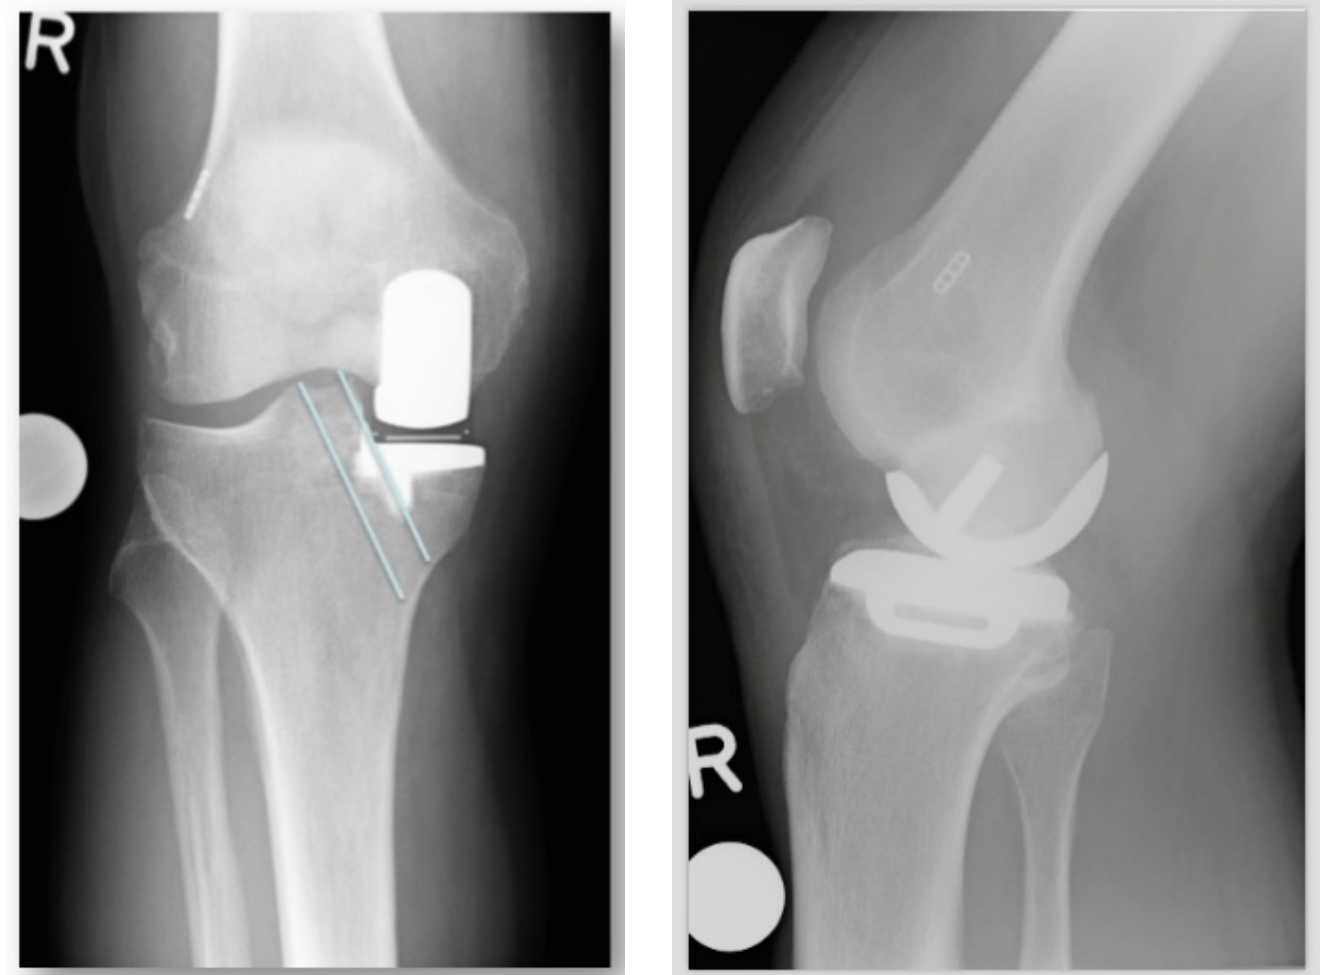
+2: post operative x-ray after ACL Reconstruction and Unicondylar Knee Replacement
